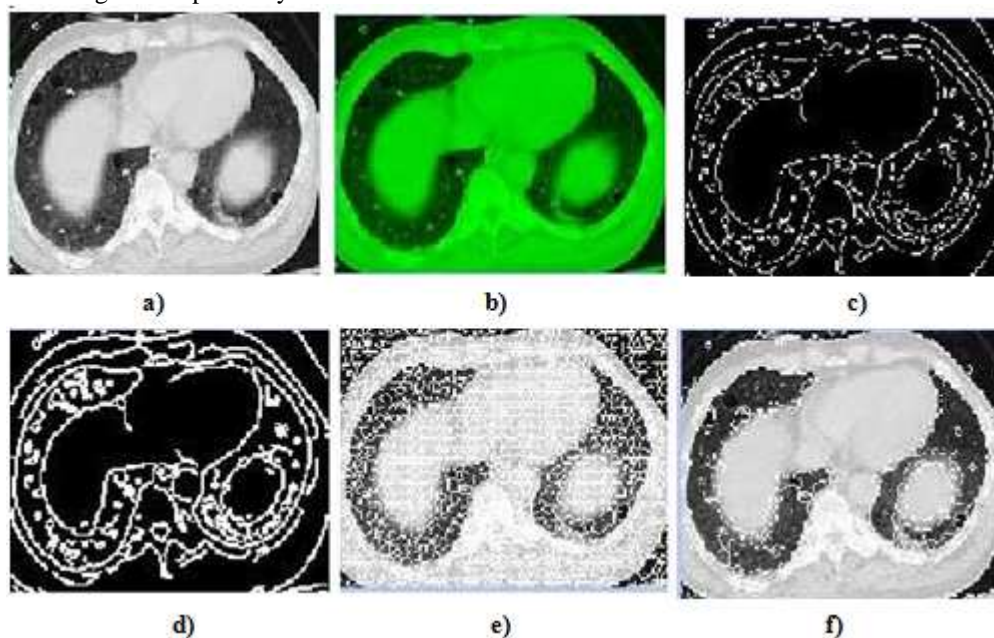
Segmentation steps for CT Image a) input denoised image, b) green layer separation, c) gray level intensity, d) edge detection, e) morphological processing f) segmentation, g) superpixel segmentation
